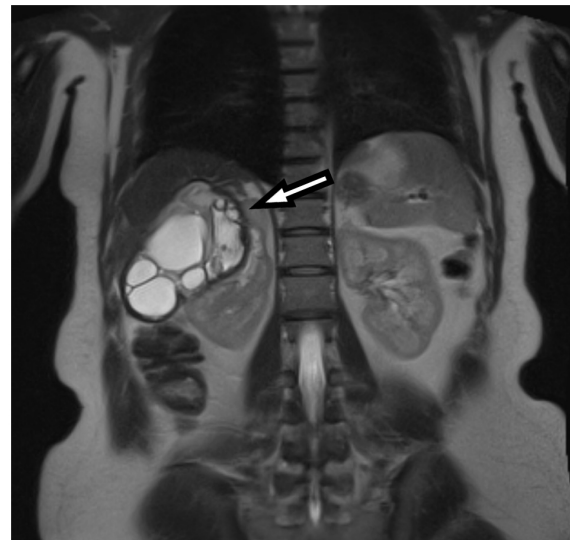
MRI image of a hydatid cyst in the right kidney. Daughter vesicles are seen within the cyst (arrow).
